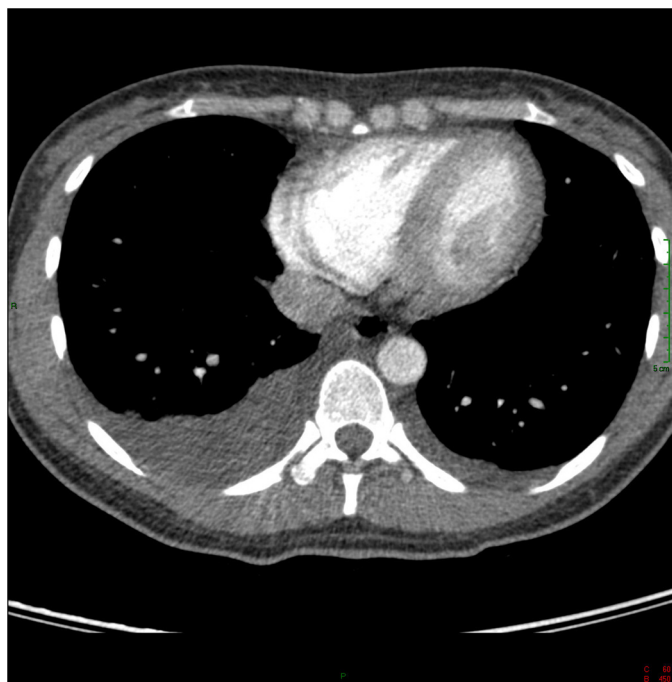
Computed tomography image of the thorax showing bilateral pleural effusion.
